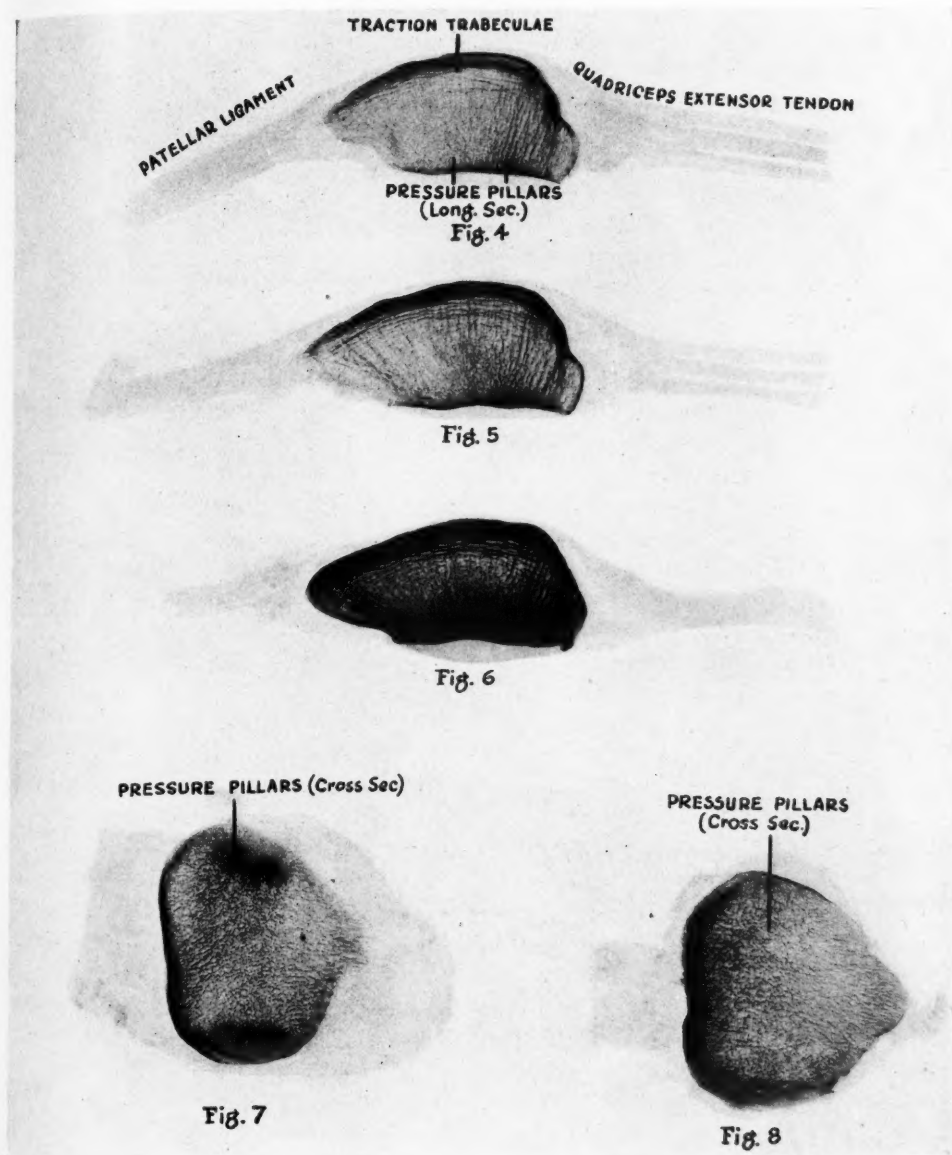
Figs. 4, 5, and 6. Roentgenograms of human patellae, mid-sagittal sections 1 mm. thick. These mid-sagittal sections are of different human patellae, showing the similar arrangements of the traction trabeculae and pressure pillars in this plane of section (natural size).
